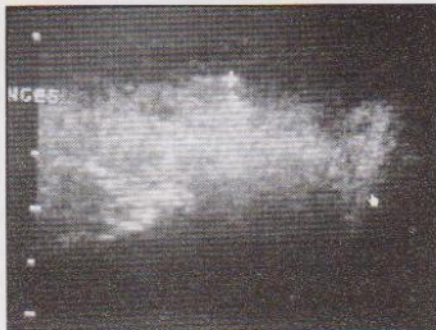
Ultrasound with Appliance.
